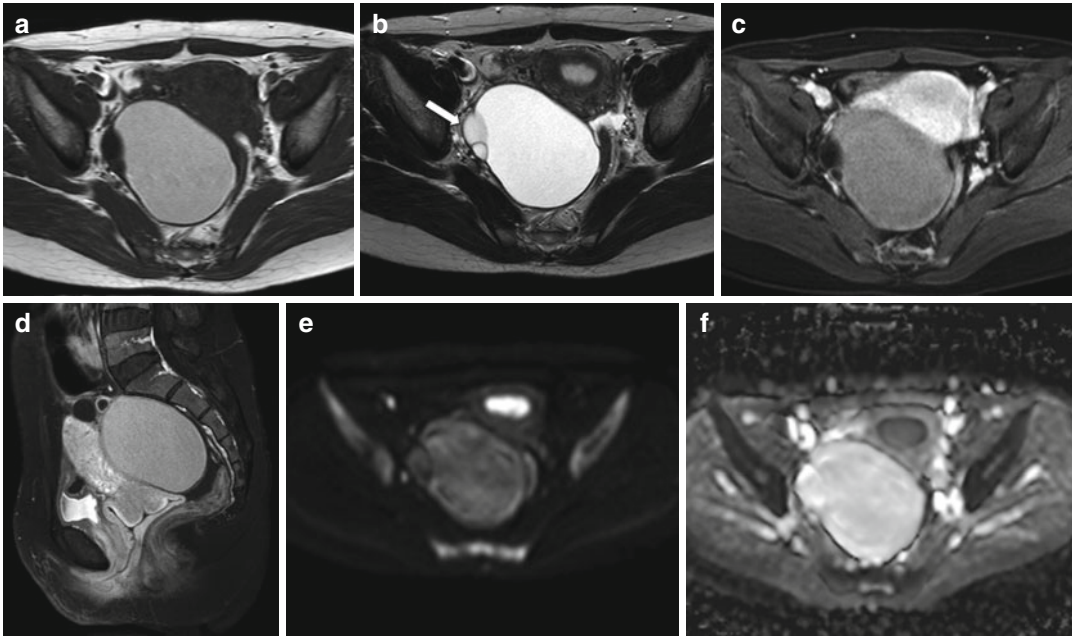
Benign serous cystadenoma. A 32-year-old woman with a right adnexal cystic lesion showing thin septa on the right wall (*arrow*). The largest component shows high signal on T1-weighted (TR:519, TE:10; a) and T2-weighted imaging (TR:4361, TE:80; b) suggestive of hemorrhagic and/or proteinaceous contents. The remainder of the complex lesion shows low signal on
